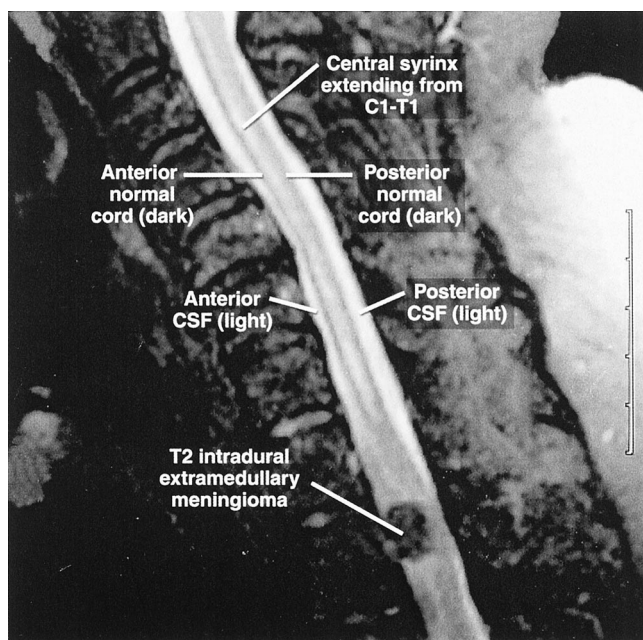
Scan of the T2-weighted saggital section of the cervical spinal cord magnetic resonance imaging performed 25 months post-interscalene block in patient 2 showing one in-continuity C1-T1 intramedullary spinal cord lesion consisting of a central myelomalotic syrinx and a T2 intradural but extramedullary mass (during axial view the position of the mass was right anterolateral).
